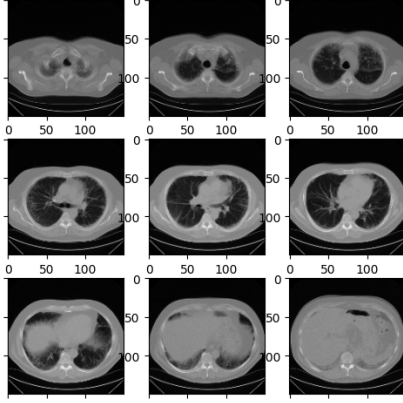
The example of chest CT scan slices in the dataset [4].
